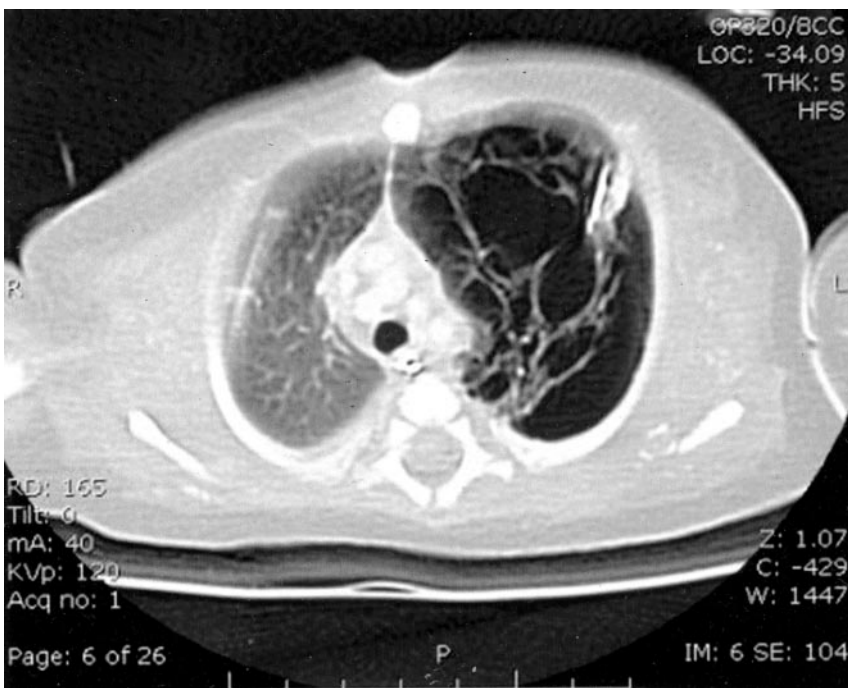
Axial cut image from chest CT showing macrocystic changes of left lung consistent with unilateral pulmonary emphysema.
